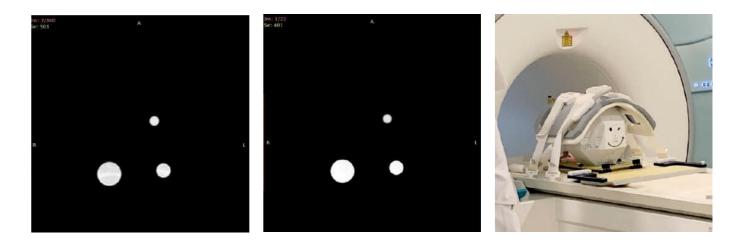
Left: T1 sequence, Center: T2 sequence, Right: RUBY at 3 T MRI.
